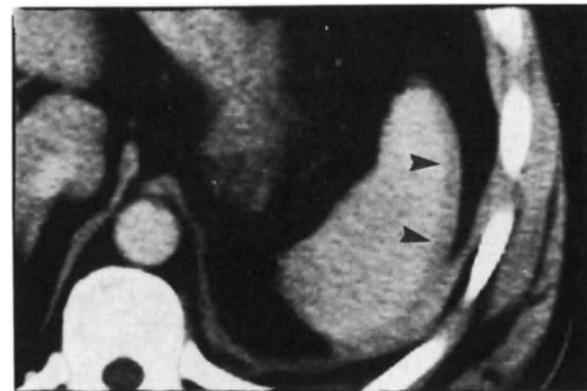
CT scan. Enhanced. Subcapsular hematoma of spleen (arrows) following stab wound.
